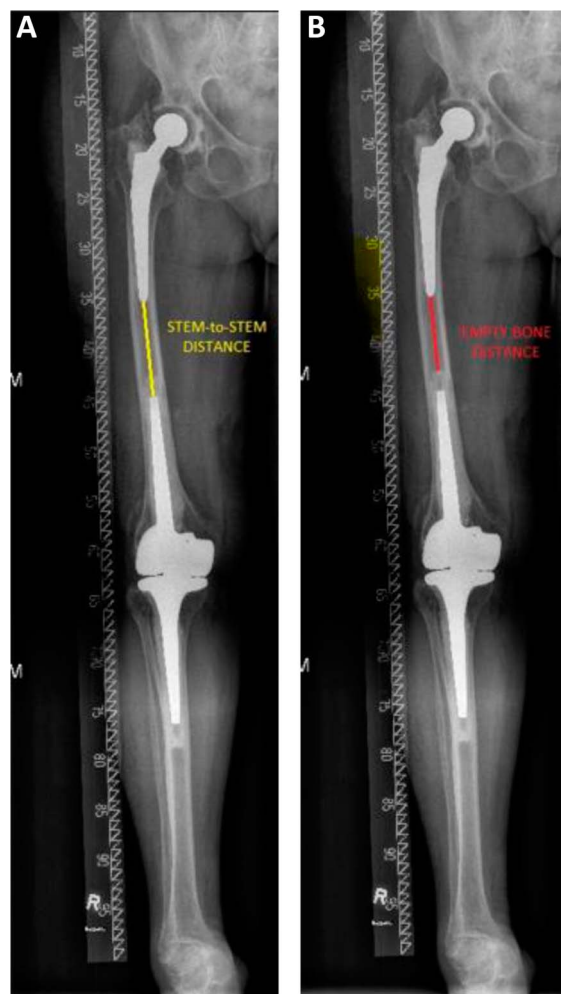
Radiographic measurement of the (A) stem-to-stem distance and (B) the empty native bone distance is shown in a revision TKA.
